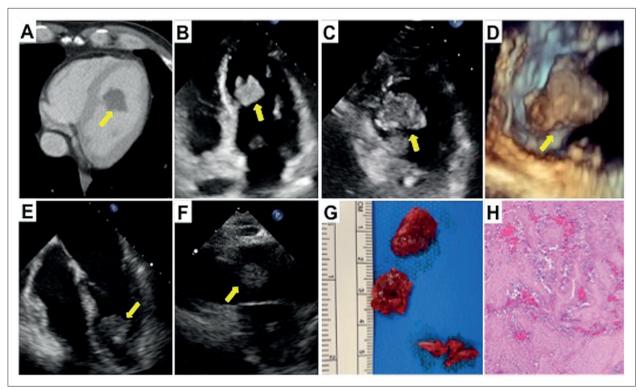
A*) Chest computed tomography (CT) Scan. Filling defect in the left ventricle (arrow). B) 2D-Transthoracic echocardiogram. 4-axis-view. Pedunculated hyperechogenic mass (arrow). C) 2D-Transthoracic echocardiogram. The mass (arrow) in short-axis-view. D) 3D-Transthoracic echocardiogram. Mass anchored to the septum of left ventricle (arrow). E) 2D-Transesophageal echocardiogram. 4-chamber-view. Mass anchored to the septum of left ventricle (arrow). E) 2D-Transesophageal echocardiogram. 4-chamber-view. Mass anchored to the septum of left ventricle (arrow). F) Thrombus in the right pulmonary branch (arrow). G) Surgical piece removed from the left ventricle. H) Pathological anatomy of the thrombus.
